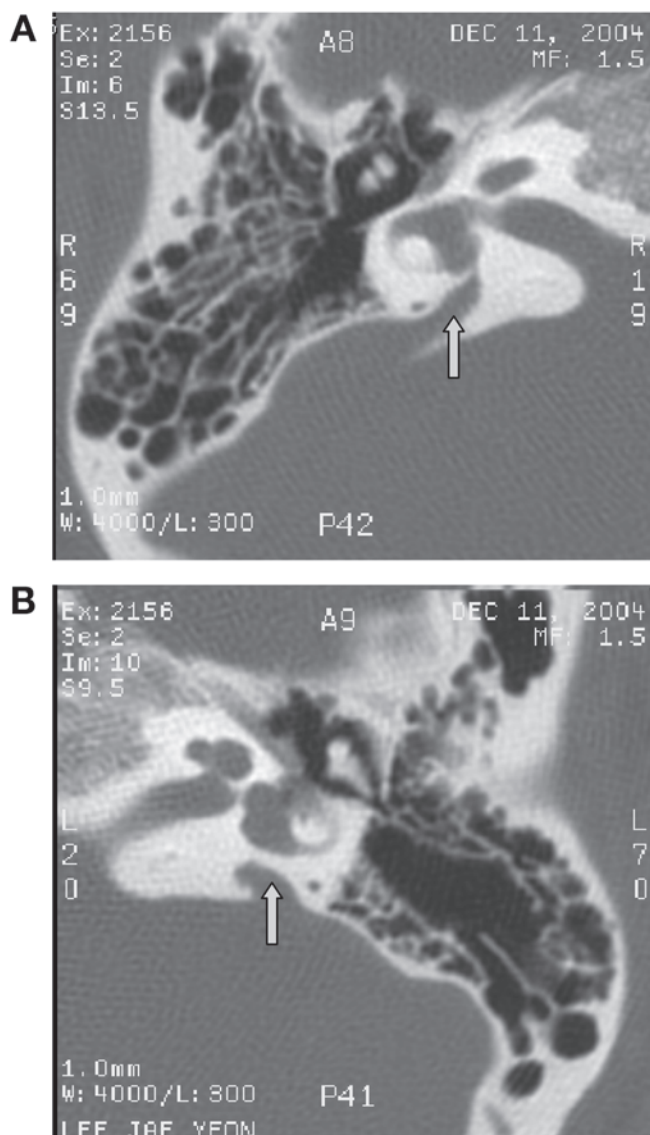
Axial computed tomographic images of the temporal bones showing enlarged vestibular aqueduct in the right (A) and left (B) inner ear of YS-1. The enlarged vestibular aqueduct is indicated by the arrow.
